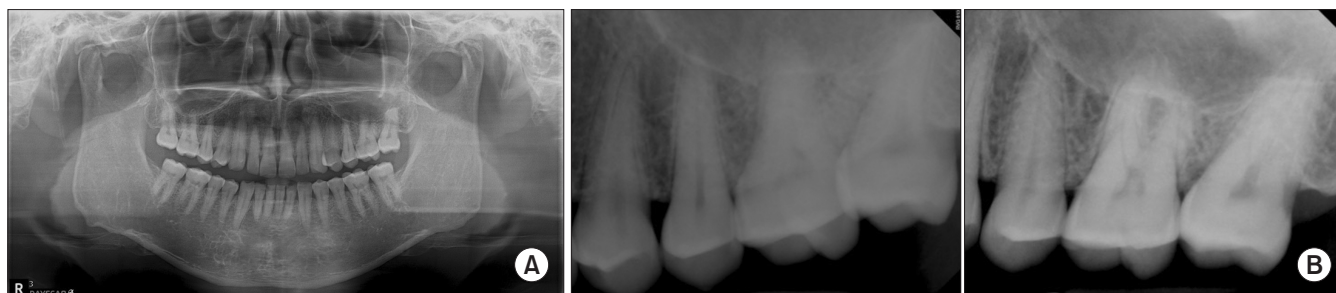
Panoramic (A) and #24-27 periapical (B) images obtained during the first visit.
